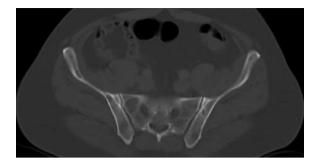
Multiple well-defined lucent bone lesions involving the pelvic bones on computed tomography (patient no. 15).
